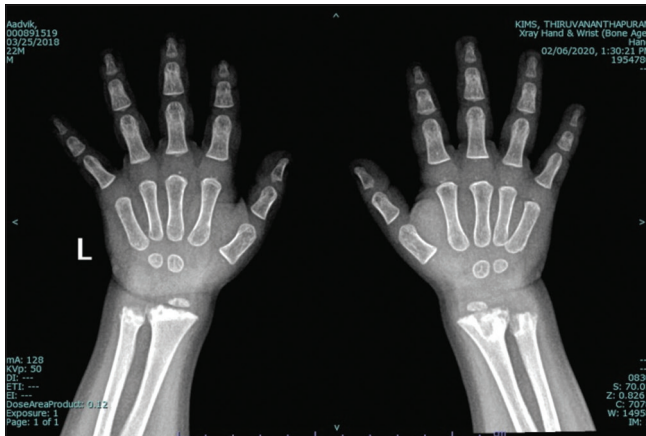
The X-ray of wrists showing irregular widened metaphyses.
